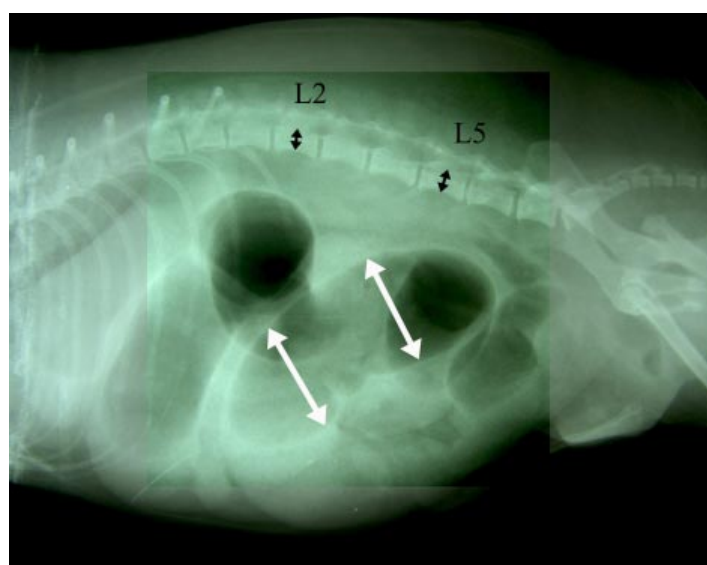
The small bowel dilatation can be easily evaluated by comparing with the height of the central part of the body of L2 or L5 which is normally seen in the plain lateral abdominal radiograph.
